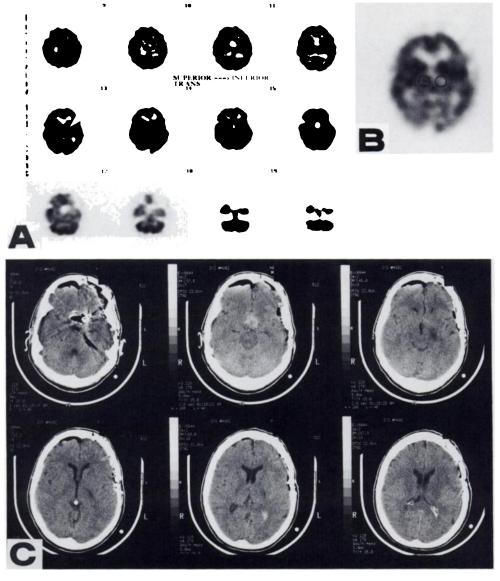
(A) Transaxial SPECT for Patient 2 shows marked hypoperfusion of the left posterior limb of the internal capsule (white arrow) on the first postoperative day after clipping of a giant aneurysm. Midline photopenic defect seen best on the last image in the middle row is the site of the giant aneurysm. Defect in the left inferior front-temporal region is the operative site. (B) ROI placement for Patient 2 for left versus right statistics. (C) Noncontrast head CT scan performed on the same day as the SPECT shows hypodensity in the posterior limb of the internal capsule on the left.
